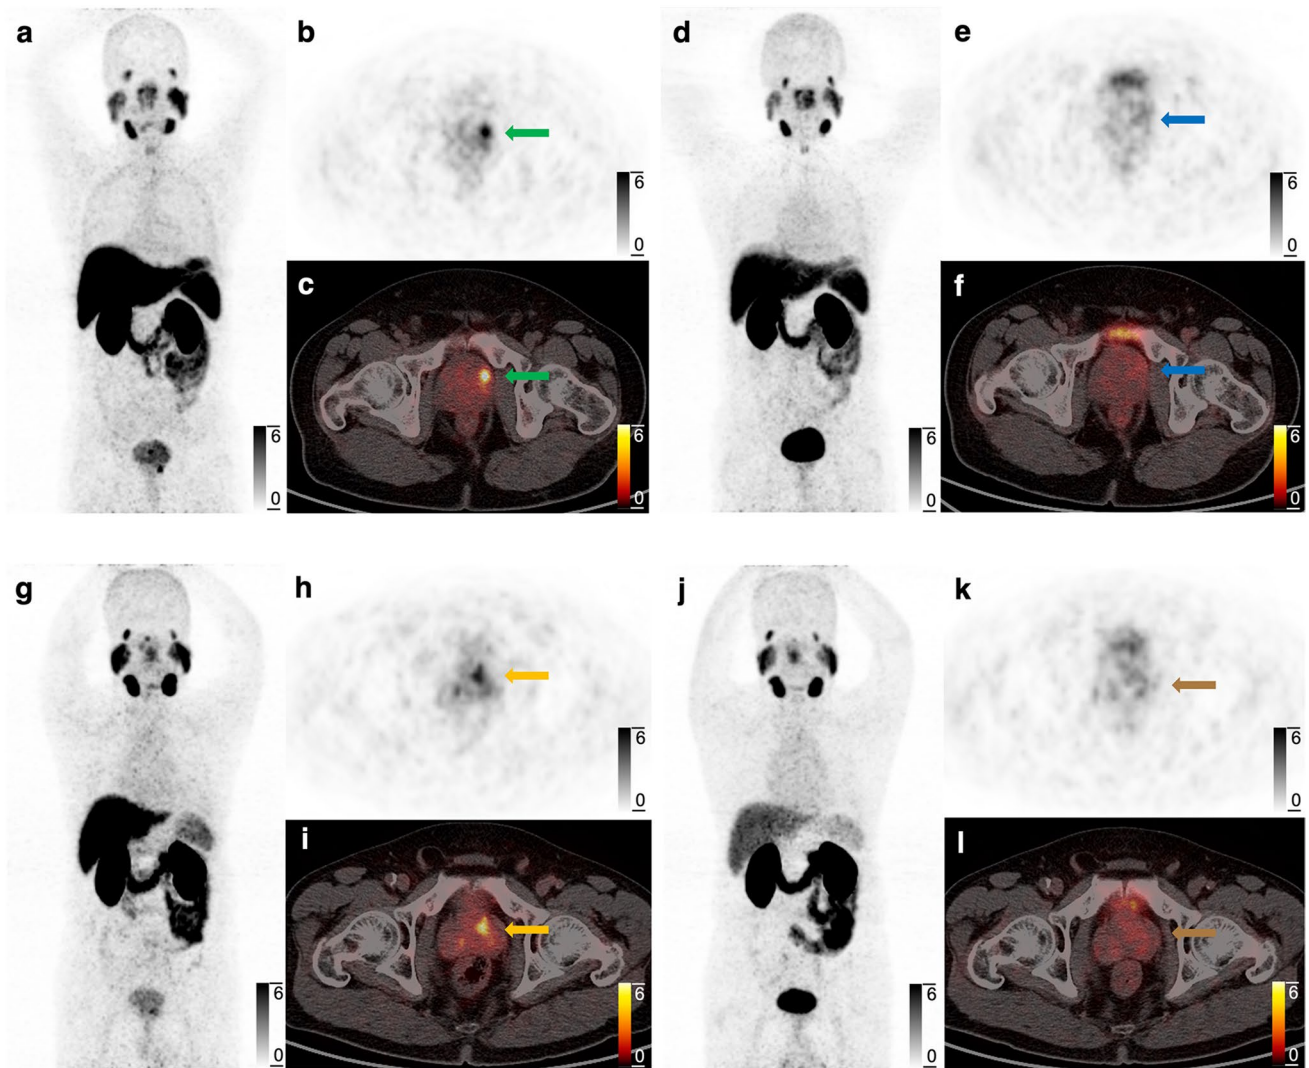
Performance of [^{68}Ga]Ga-P16-093 and [^{68}Ga]Ga-PSMA-11 PET/CT in two patients with primary prostate cancer. (First row) A 68-year-old male with a Gleason Score of 3+4 and a PSA level of 16.8 ng/mL. [^{68}Ga]Ga-P16-093 PET/CT (a-c) revealed a PSMA-avid tumor in the prostate (green arrow, SUVmax 7.5), which was negative on [^{68}Ga]Ga-PSMA-11 PET/CT (d-f, blue arrow). (Second row)
